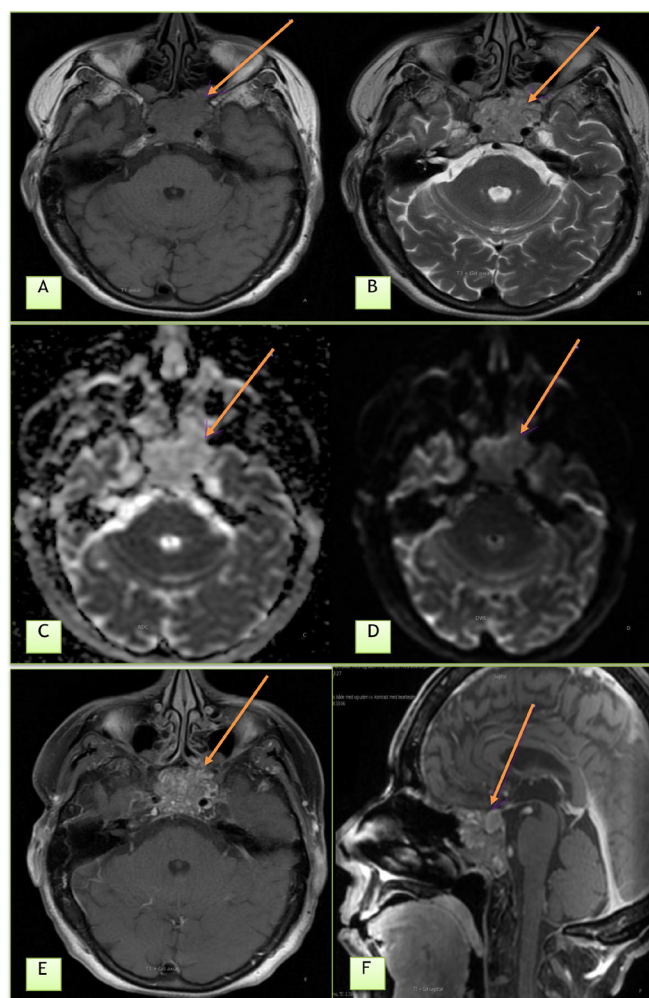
MR axial T1 without contrast shows an isointense tumour (A), axial T2 shows mild hyperintensity (B), DWI and ADC without diffusion restriction (C and D), axial and sagittal T1+gadolinium show moderate enhancement of the tumour (E and F) (Tumour has a grapelike structure that can easily be identified in T2 and T1+Gadolinium sequences).
